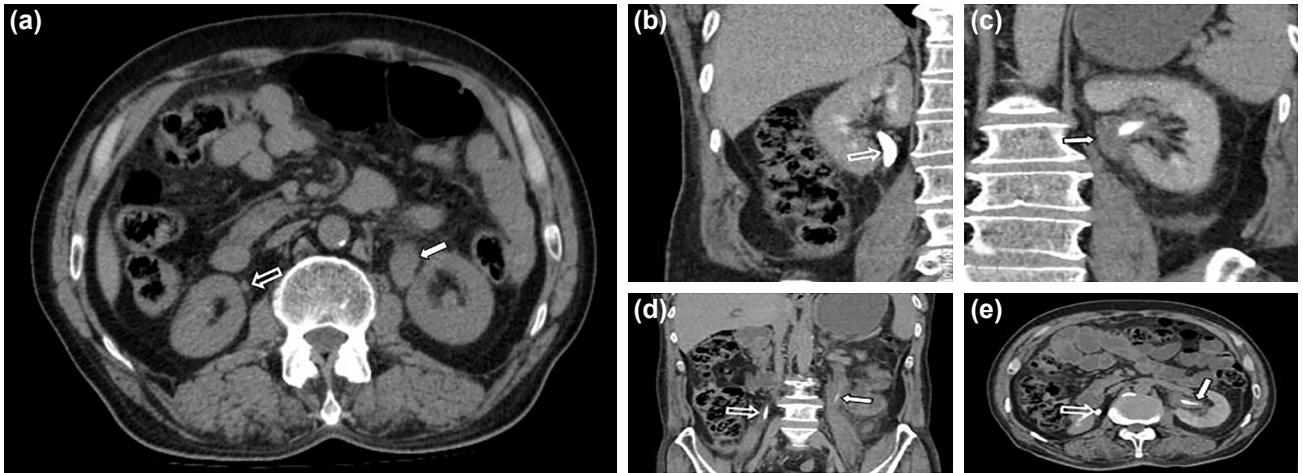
(a) The first non-contrast abdomen computed tomography (CT) showed asymmetric thick and high-density left ureter (arrow) and right ureter in normal appearance (hollow arrow). (b-e). Three days later in the pyelogram phase, contrast-enhanced coronal reformat abdomen CT showed thickening of the left renal pelvis and ureter (arrows) and normal appearance of the right renal pelvis and ureter (hollow arrows).
